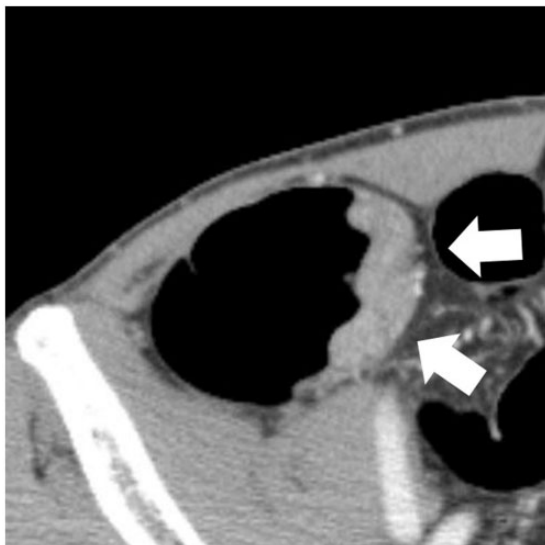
CT image of a 54-year-old man with ascending colon cancer whose longitudinal length was 23 mm. The margin of the lesion was smooth (arrow), and pericolic fat stranding was not observed around the lesion. The circumferential proportion of the tumor was $< 50\%$, and pathological diagnosis of depth of invasion was T2.
